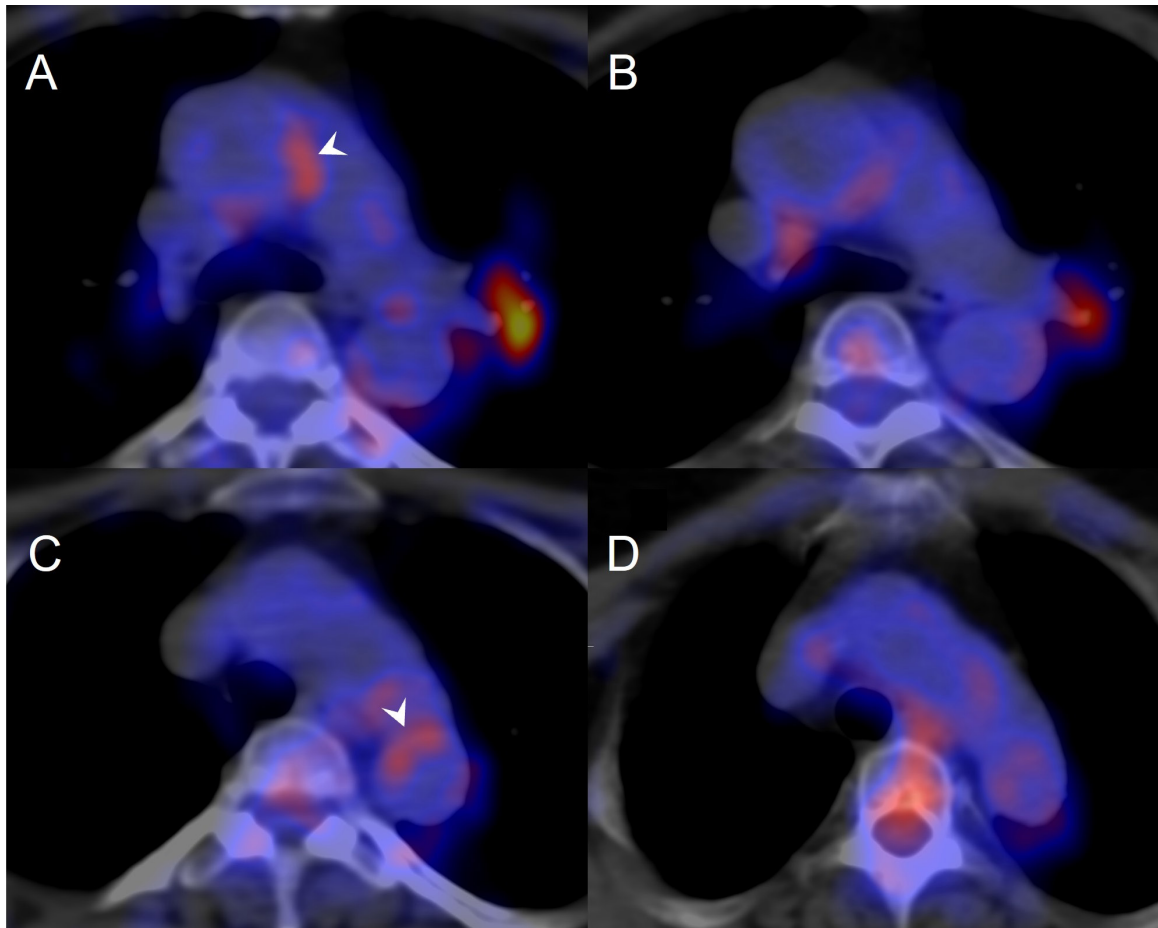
Representative image of vascular inflammation visualised by ^{18}F -FDP-PET/CT at baseline and after tofacitinib treatment in a patient baseline (C) ost-treatment (D)
